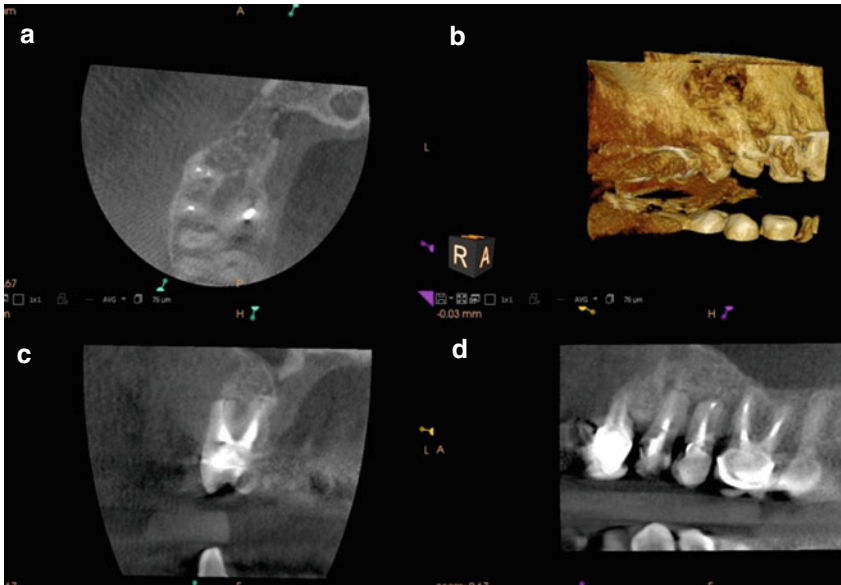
Continuation of case presented in Fig. 6.17: 12-month postoperative CBCT scan of teeth #12 and #13 demonstrating bone remodeling observed in axial (a), 3D rendering (b), coronal (c), and sagittal (d)
